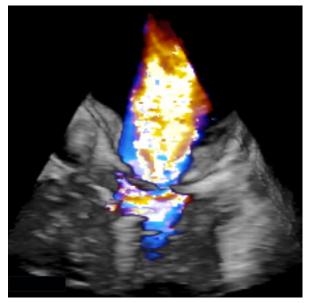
Three-dimensional transesophageal echocardiogram (color-flow Doppler mode) shows a severe mitral regurgitant jet.
